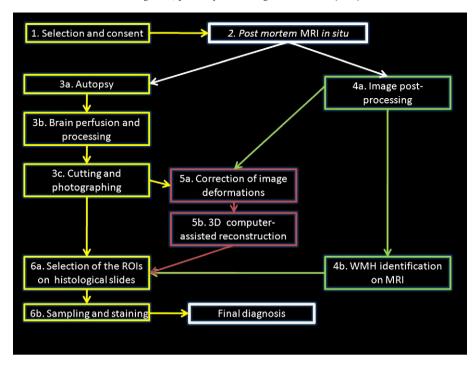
Steps of the protocol for detection of incipient vascular changes by a biotechnological platform combining post mortem MRI in situ with neuropathology. Note: ROIs — regions of interest.
